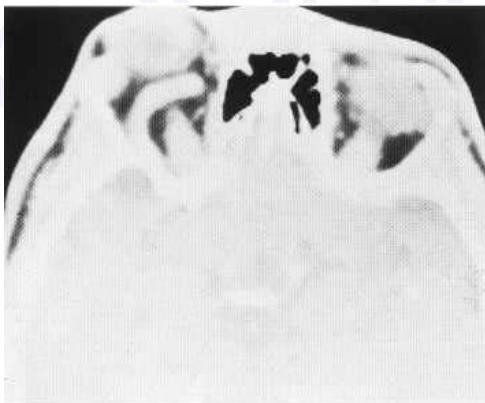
Patient with proptosis and orbital bruit due to dural AV fistula. CT shows grossly dilated superior ophthalmic vein.
